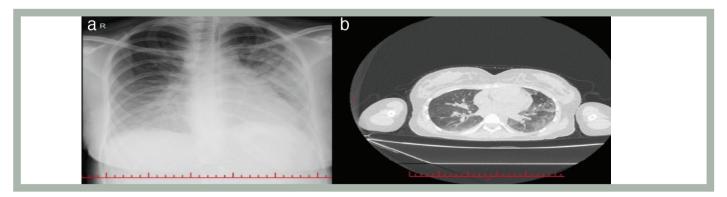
(a) Pulmonary X-ray showing diffuse bronchopneumonic infiltration. (b) Thorax computed tomography showing diffuse centroacinar densities at the superior lobe of the left lung representing bronchopneumonic infiltration and minimal effusion in bilateral fissures
